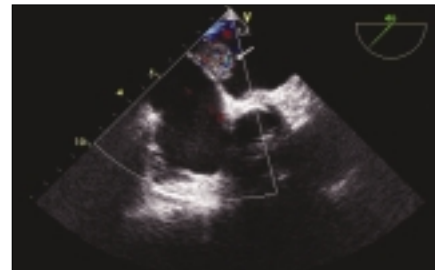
Blood flow within the mass demonstrated using color Doppler transesophageal echocardiography
